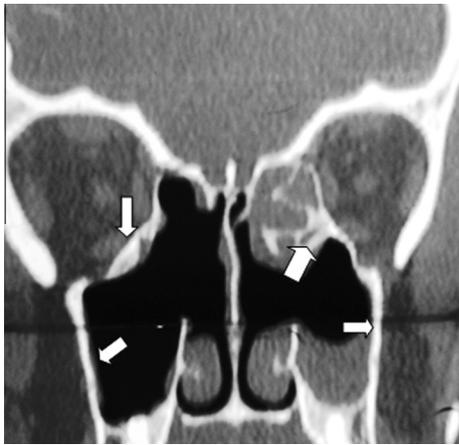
Coronal CT scan showing revision case with severe osteitis of all sinus walls (arrows).
